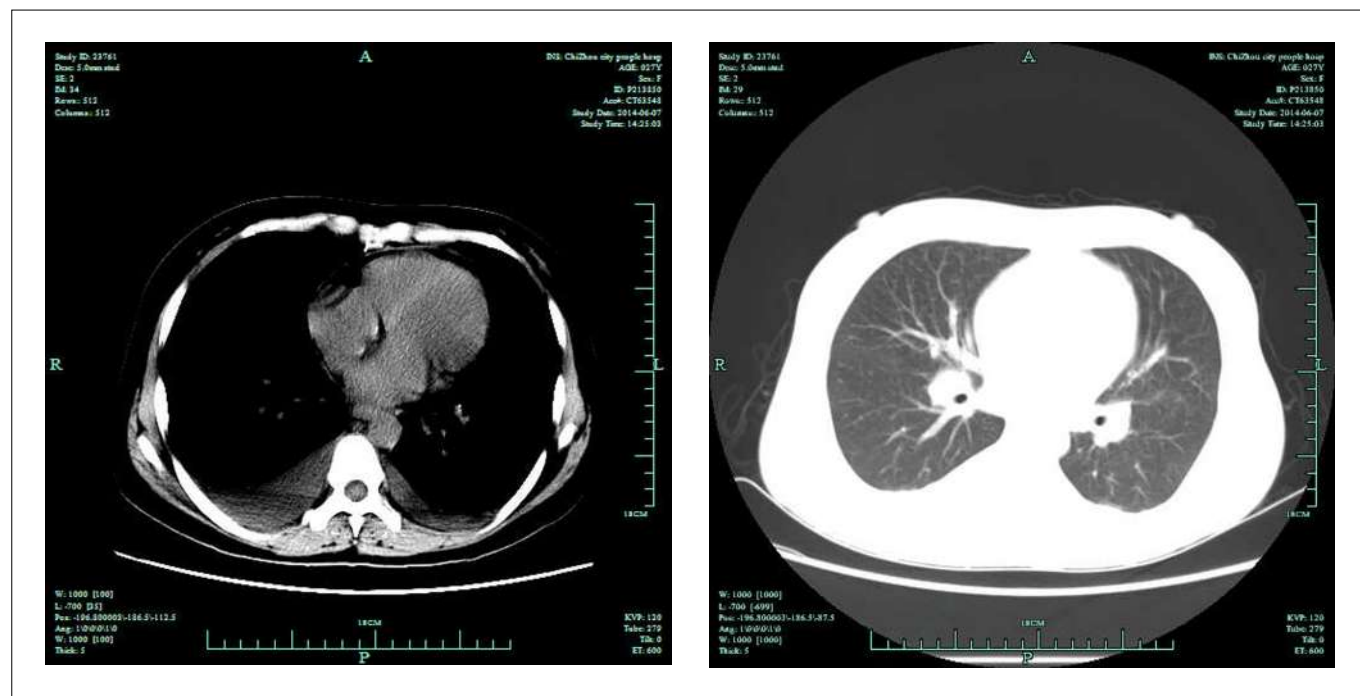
Computed tomography of the chest, revealing slight swelling of the mediastinal lymph nodes and a small amount of bilateral pleural effusion, with slightly more on the right side than on the left.
